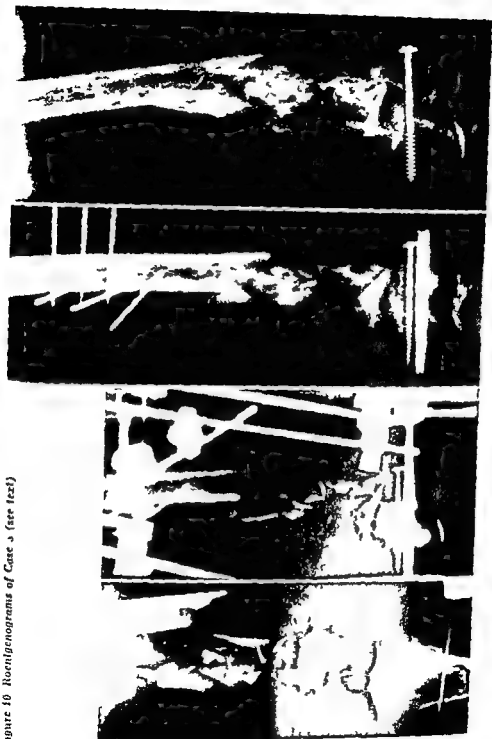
Roentgenograms of Case 3 (see text)
